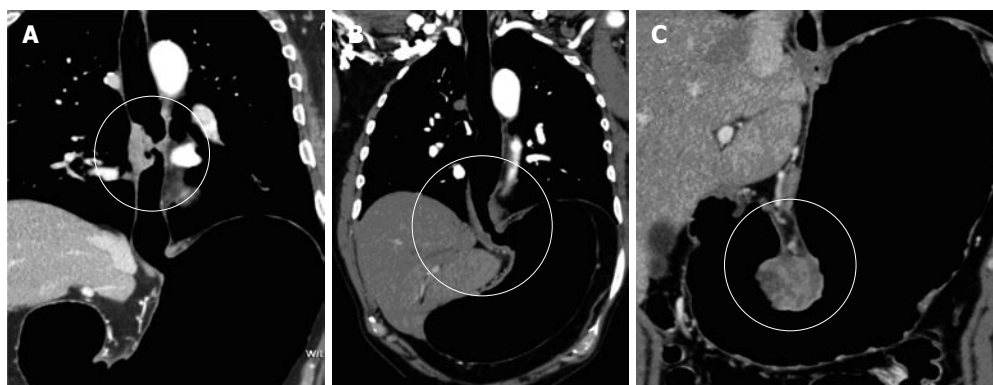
Pneumo-computed tomography in esophageal and gastric neoplasms. A: Pneumo-computed tomography (PnCT) multiplanar reconstructions (MPR) coronal soft tissue window reconstruction depicting involvement of mid-thoracic esophagus. Note detailed demonstration of location; B: PnCT MPR coronal soft tissue window reconstruction depicting involvement of the gastroesophageal junction; C: PnCT MPR coronal soft tissue window shows a GIST tumor arising from gastric wall.
